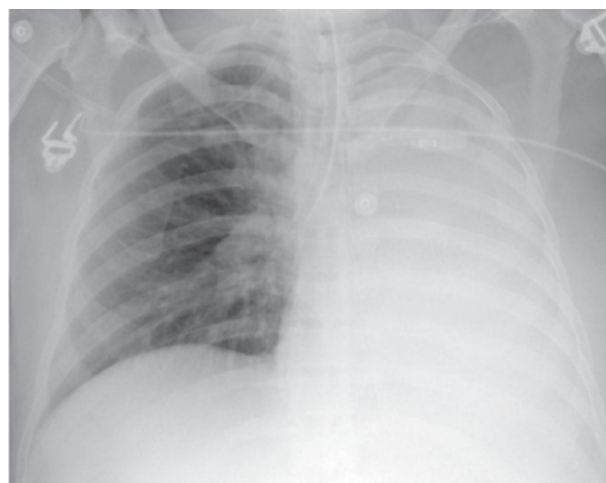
Chest Xray of patient 3
